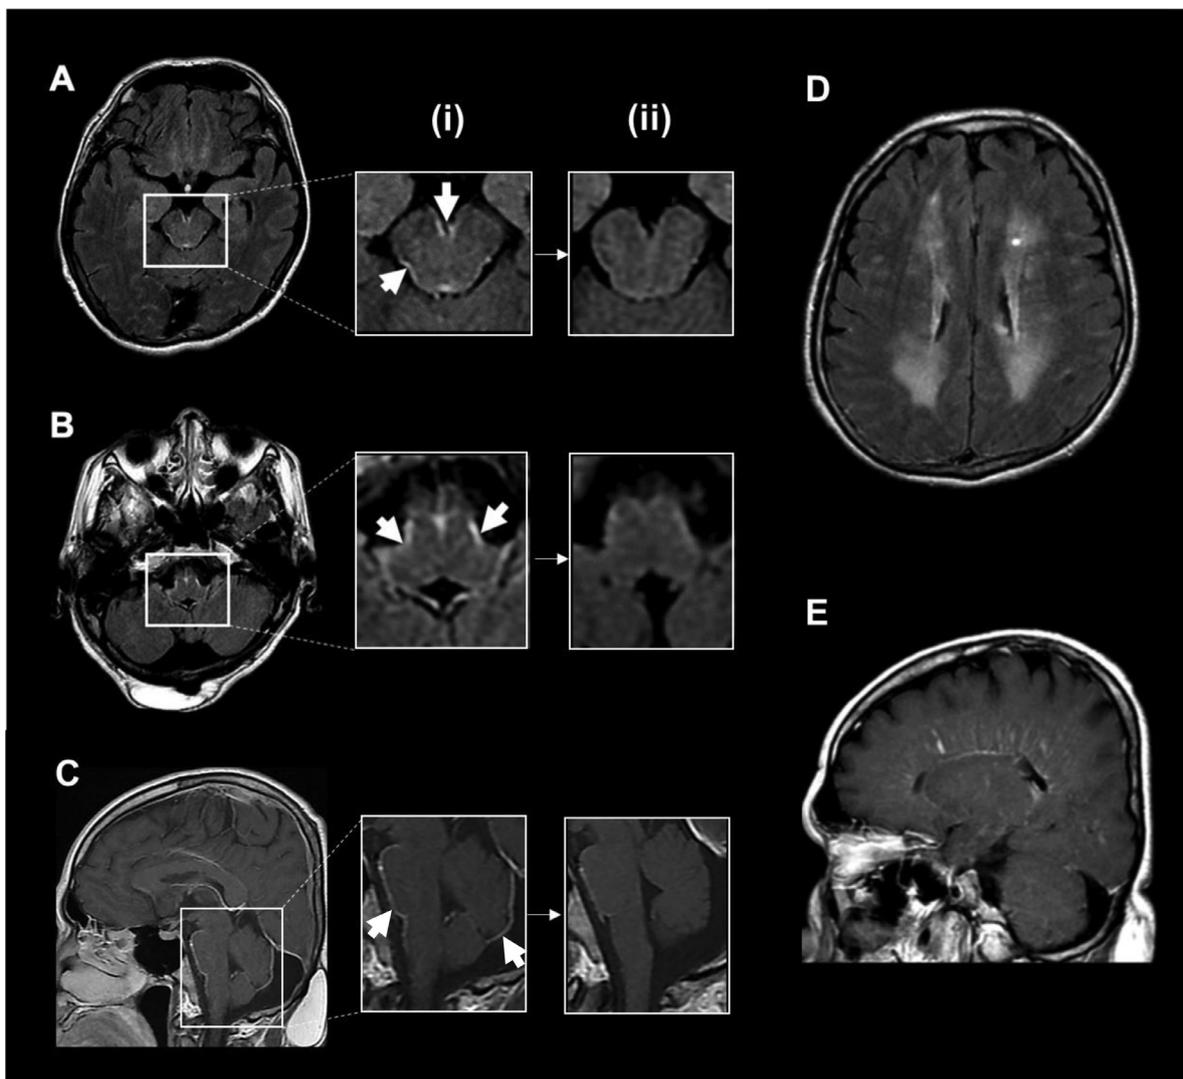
MRI brain scans. MRI postcontrast axial fluid attenuated inversion recovery scans reveal leptomeningeal enhancement of the pons (a) and medulla (b), whereas sagittal T1-weighted scans reveal diffuse leptomeningeal uptake of gadolinium in the pons, medulla, and cerebellum (c), as highlighted by the bold arrows in images a (i), b (i), and c (i). A 2-week treatment with dexamethasone and antituberculous medications resulted in improvement and resolution in leptomeningeal enhancement as shown in images a (ii), b (ii), and c (ii). After steroid discontinuation, he developed further clinical deterioration. A repeat MRI of the brain revealed new findings of diffuse periventricular and deep white matter hyperintensities on axial fluid attenuated inversion recovery images (d), as well as linear, periventricular pattern of enhancement radiating from the periventricular region on gadolinium-enhanced sagittal T1-weighted images (e). Abbreviation: MRI, magnetic resonance imaging.
